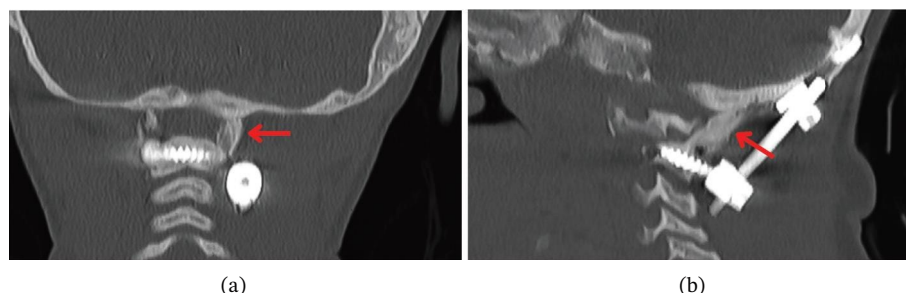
Computed tomography images show bridging bone formation at 6 months with coronal plane on (a) and sagittal plane on (b). Bridging bone formation is more extensive on the left side at the fixation level (red arrows).
